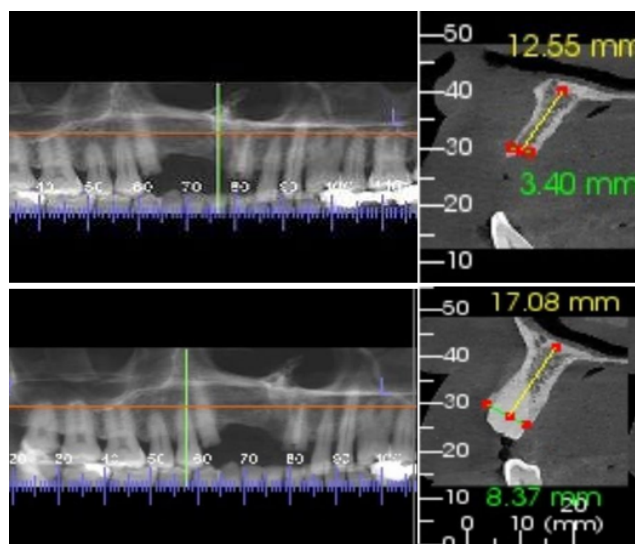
Radiographic evaluation (CBCT Scan)
